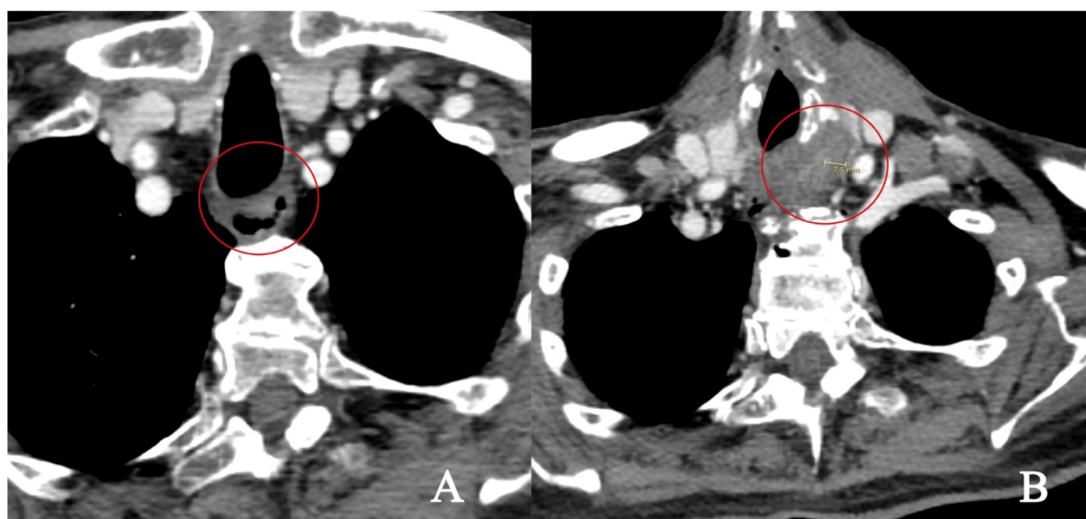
Computed Tomography (CT). Red circles (A; B) show esophageal wall thickening with perilesional enhancement (B, 7.5 mm) compatible with edema and inflammation.
